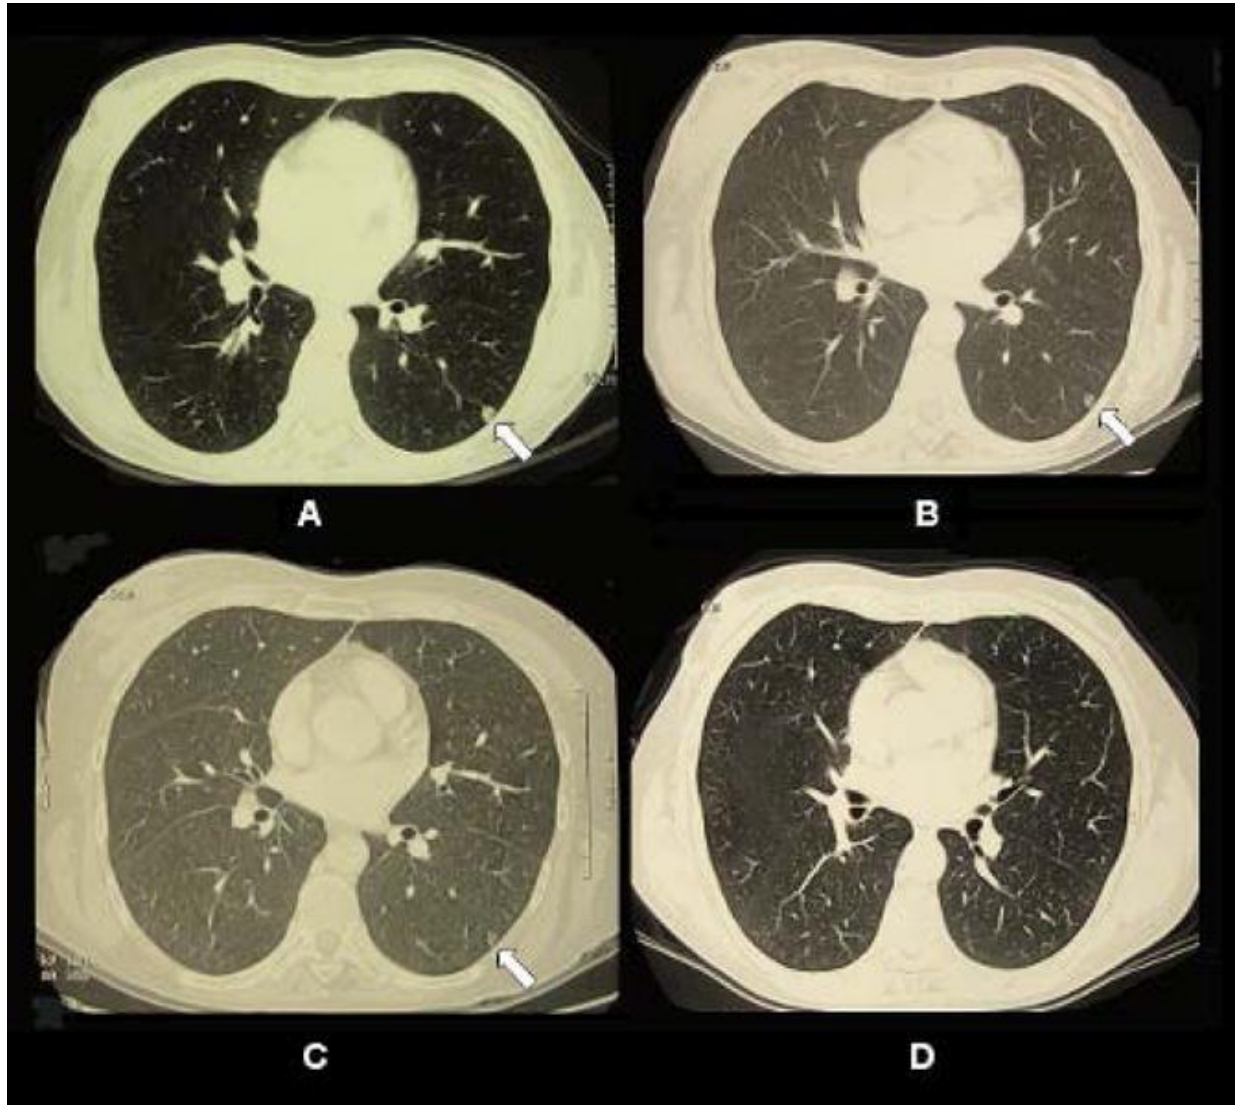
Previous results using LIT. This figure is from a study that can be found in (Li, 2011). The figure shows CT scans of pulmonary metastatic nodule in the left lung of a late-stage breast cancer patient. The nodule is marked by the arrow in images A-C. It depicts the progression of tumor reduction in response to laser immunotherapy treatment. Image A is at the pre-treatment time point, image B at 1 week-post treatment, image C at 2.5 months post-treatment, and image D at 12 months post-treatment.
